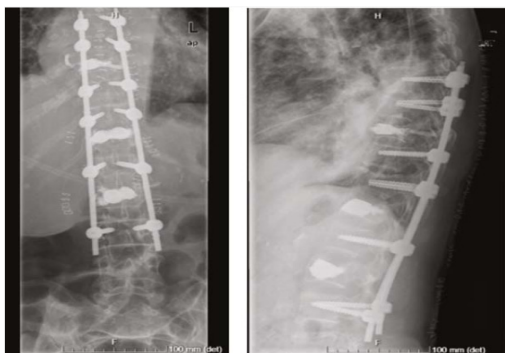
Post-operative radiograph of Kyphoplasty for correction of D9, D12 and L2.
